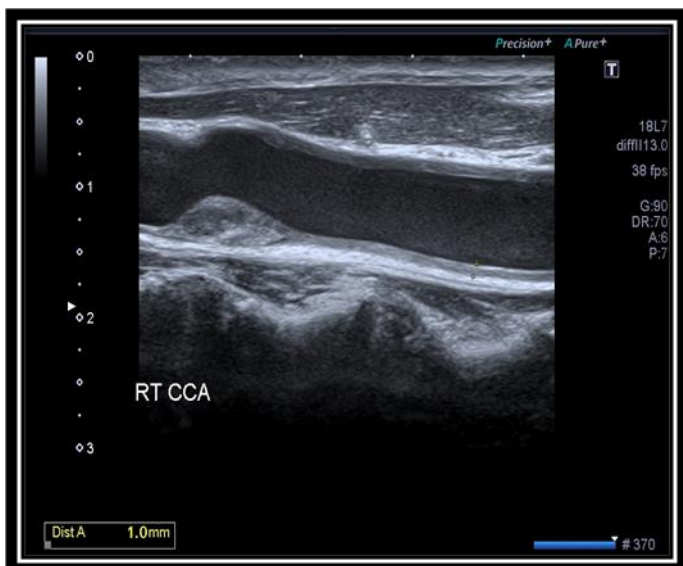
A 65-years old hypertensive male patient complained of typical chest pain. (A) and (B) Axial sections of non-contrast CT (NCCT) scan of the coronary arteries show left and right coronary calcification with Agatston Ca score of 1536. (C) 3D volume rendered image of the left coronary artery tree show heavy coronary calcification. (D) and (E) Longitudinal US images of RT CCA show CIMT of 0.9 mm associated with mixed atheromatous plaque 15x3 mm. The patient was assigned as CAC-DRS 3.
